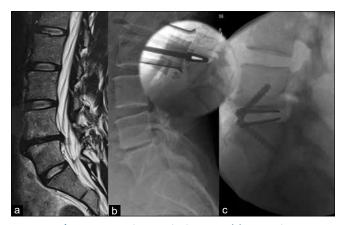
L4/5 Anterior Lumbar Interbody Fusion. (a) Severe degenerative disc disease following multiple microdiscectomy procedures with progressive disc height loss, foraminal stenosis with symptoms of discogenic low back pain and L4 radiculopathy. (b) Preoperative lateral X-ray. (c) L4/5 Anterior Lumbar Interbody Fusion with Titanium/Polyetheretherketone device.(Insert) Intraoperative trial prosthesis
